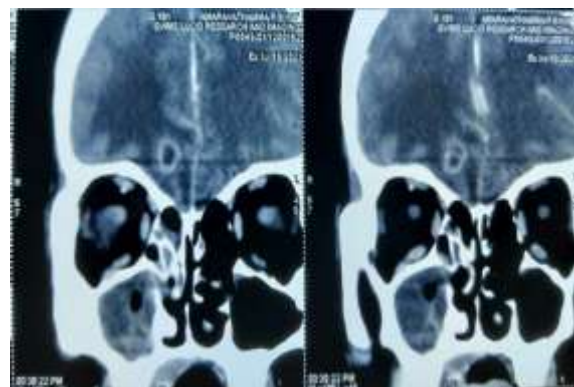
Coronal CT scan of the paranasal sinuses demonstrating features suggestive of rhino-orbito-maxillary mucormycosis, including soft tissue density within the maxillary and ethmoid sinuses with mucosal thickening, sinus opacification, and evidence of bony erosion suggesting invasive fungal sinusitis
